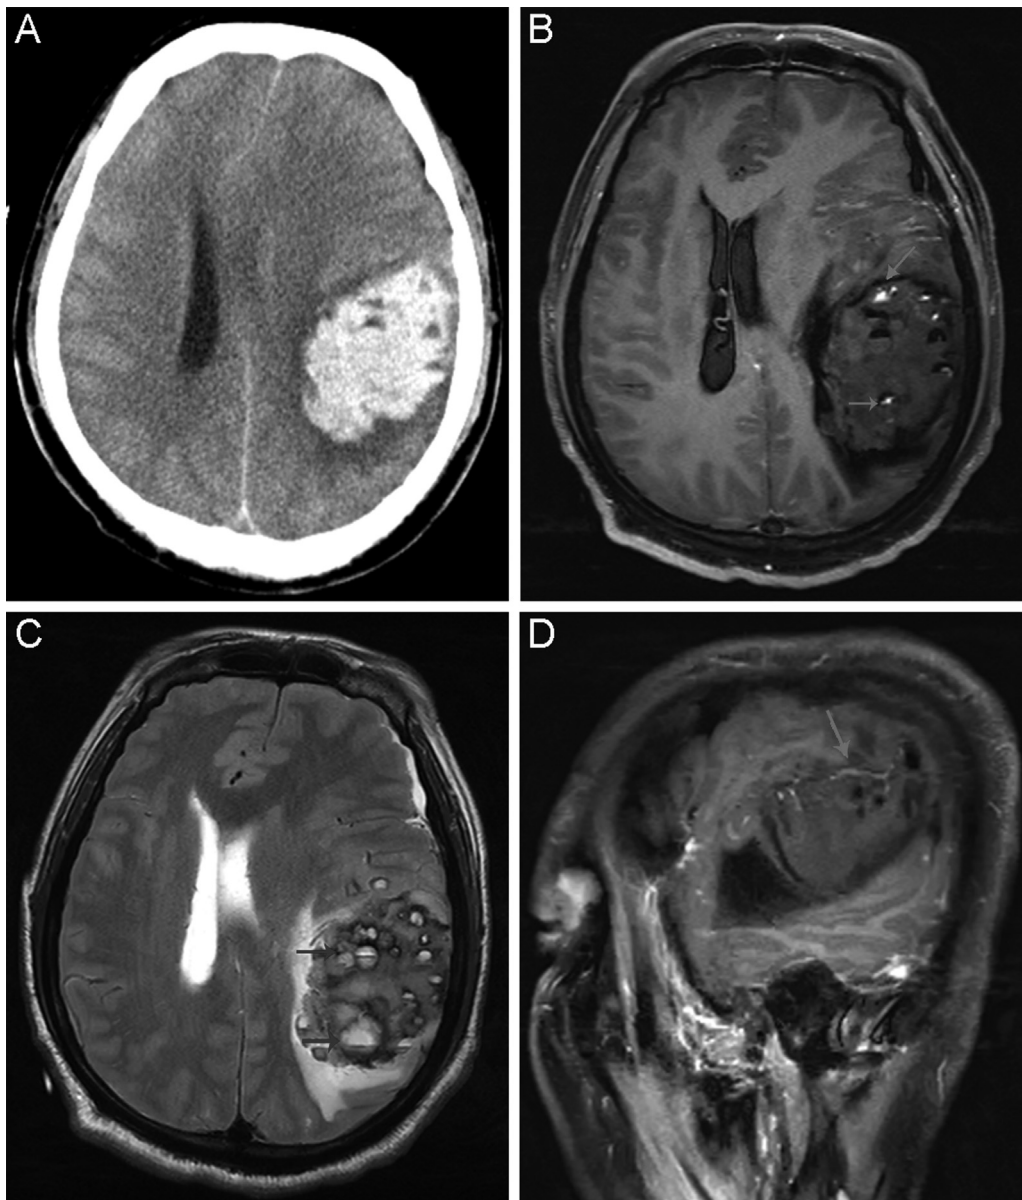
Representative images showing cerebral hemorrhage (CM) and cerebral arteriovenous malformation in the left temporo-parietal lobe. (A) Horizontal CT scan imaging shows a 63 mm × 40 mm high-density hematoma in the left temporo-parietal lobe, which results in oppressed left cerebral ventricle and remarkable right-skewed midline. (B, C) Representative horizontal magnetic resonance imaging (MRI) photographs of CM and cerebrovascular malformation. Apparent edema surrounding hemorrhagic tissues was shown (B) mass of hypointense in T1WI. (C) mass with inhomogeneous intensity in T2WI. (D) Vertical MRI scan of cerebrovascular malformation. The red arrow shows contrasted malformed cerebral vasculature, the blue hemorrhagic and inflammatory necrotic brain tissues.
